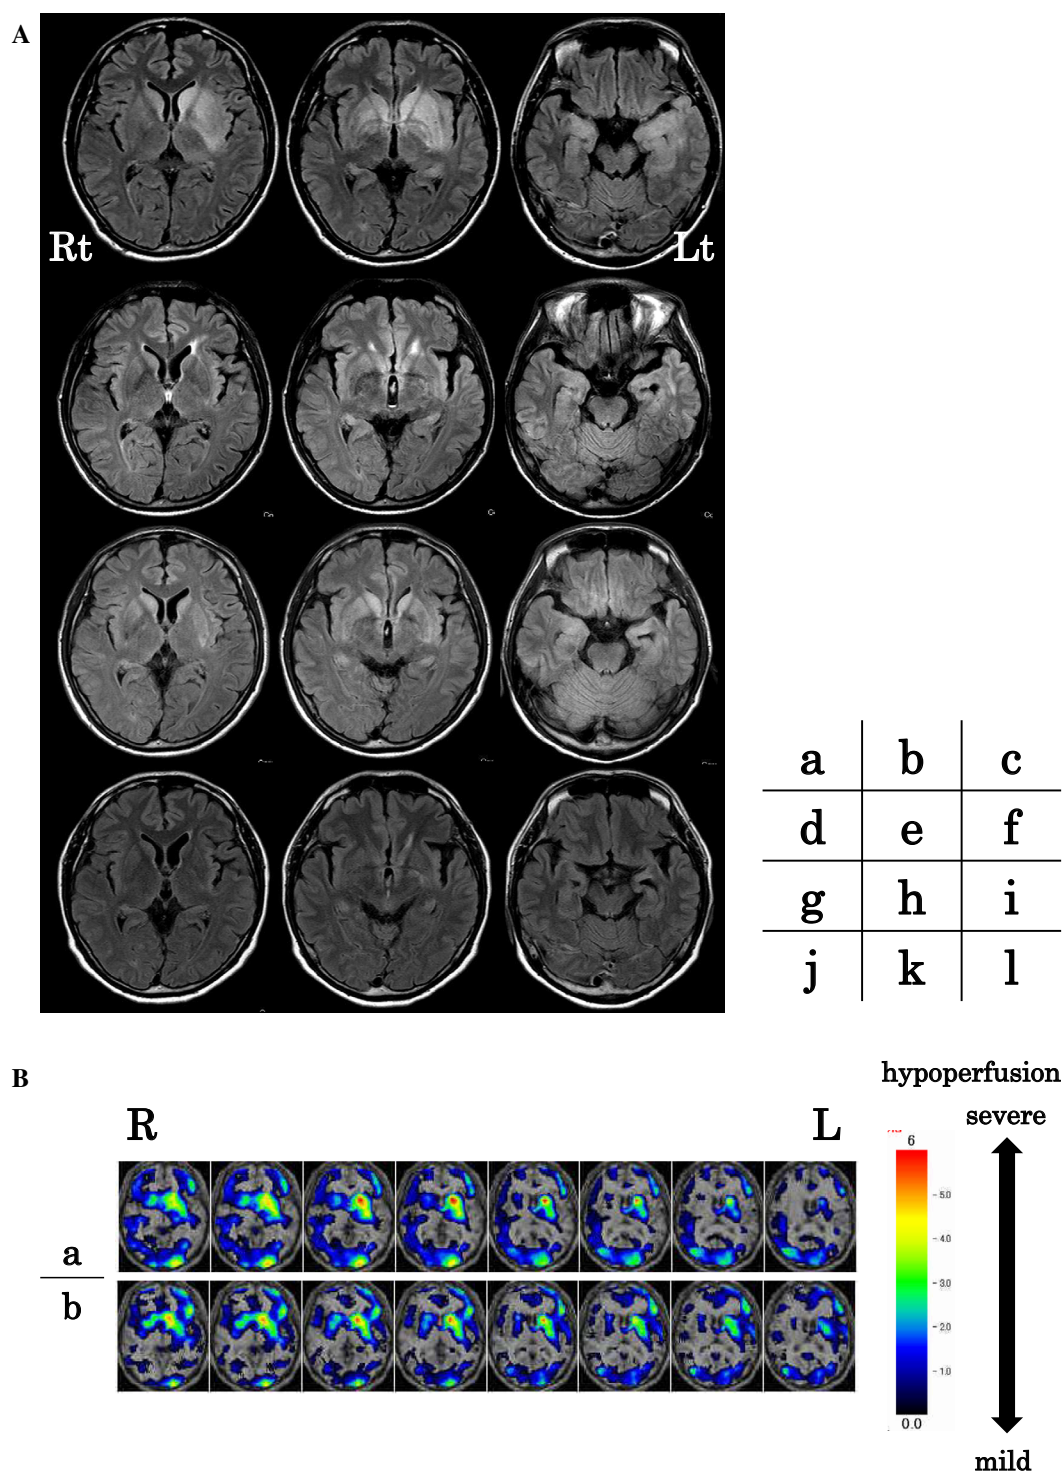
(A) MRI FLAIR images obtained at admission and during the therapeutic course. (B) ^{99m}Tc SPECT performed at onset and at relapse of the encephalitis. (A) Magnetic resonance imaging (MRI) on admission showed high signal intensities in the bilateral medial temporal lobes and basal ganglia, predominantly on the left side, on fluid-attenuated inversion recovery (FLAIR) images (a-c), as well as mild swelling of the head of the caudate nucleus and medial temporal lobe on the left side. After treatment with steroid pulse therapy and intravenous immunoglobulin (IVIG), the high signal intensities became less prominent, and the head of the caudate nucleus and medial temporal lobe on the left side turned slightly atrophic (d-f). Recurrent high signal intensities in the bilateral medial temporal lobes and the head of the caudate nucleus, predominantly on the right side, were observed at relapse (g-i). The high signal intensities disappeared after re-treatment (j-l). (B) ^{99m}Tc single photon emission computed tomography (SPECT) at onset revealed hypoperfusion in the bilateral basal ganglia, which was most severe in the left caudate nucleus (a). At relapse, severe hypoperfusion in the left basal ganglia was still observed (b).
